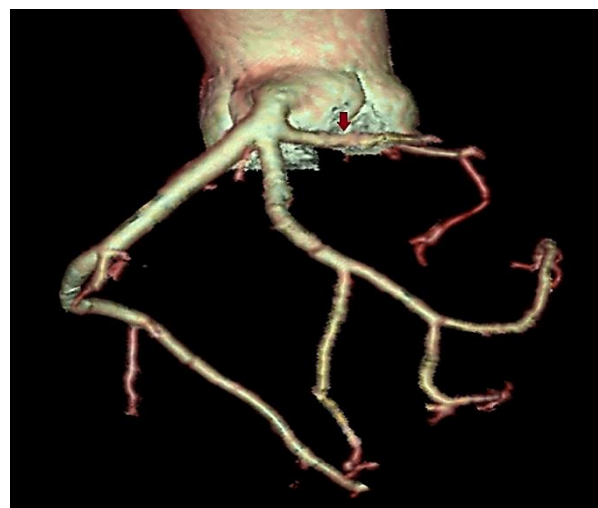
Multidetector computed tomography (MDCT) coronary angiography showing trifurcation of left main artery into left anterior descending (LAD), left circumflex (LCX), and right coronary artery (RCA) (red arrow: RCA)
